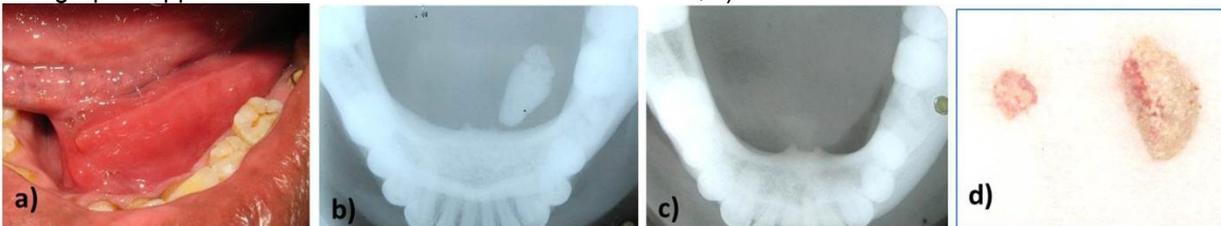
a) Left submandibular sialolithiasis in Wharton's duct, b) Occlusal radiograph showing radiopaque calculi in left floor of mouth, c) Sialolith measuring 15mm x 10mm, d) postoperative occlusal radiograph
